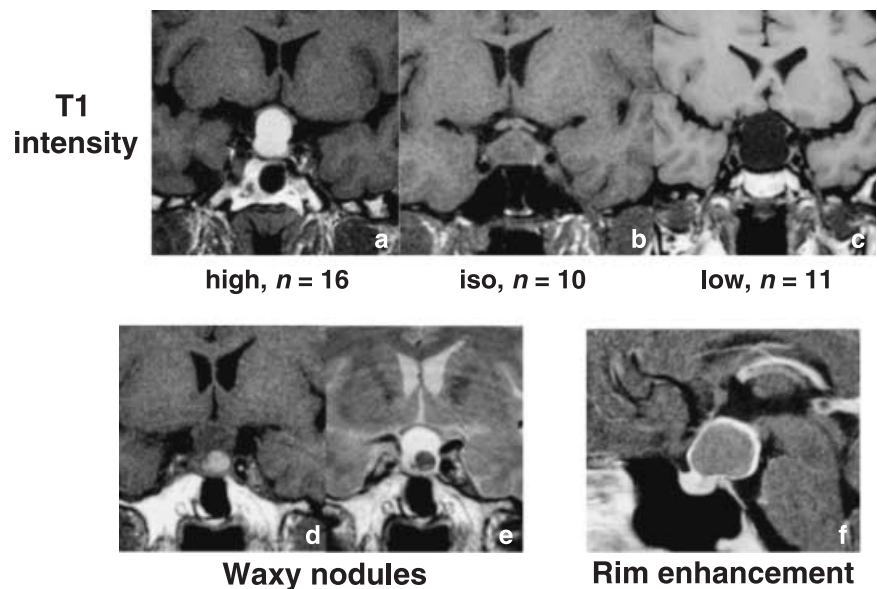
T1-weighted coronal (a–e) and Gd-contrast-enhanced sagittal (f) MRI of Rathke's cleft cysts. Although MR intensity of the cysts is variable, it is homogeneous beside a waxy nodule, demonstrated as a T1-high (d) and T2-low (e) signal intensity mass within the cyst. (f) Entirely suprasellar Rathke's cleft cyst showing distinct rim enhancement.
